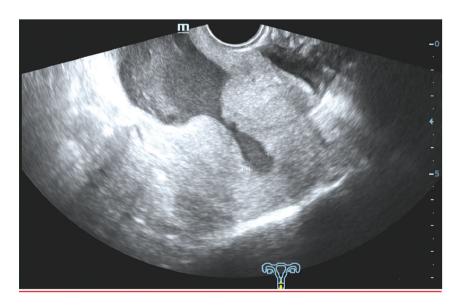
Pelvic ultrasonography showing a cystic mass in the lower segment of the uterus.
